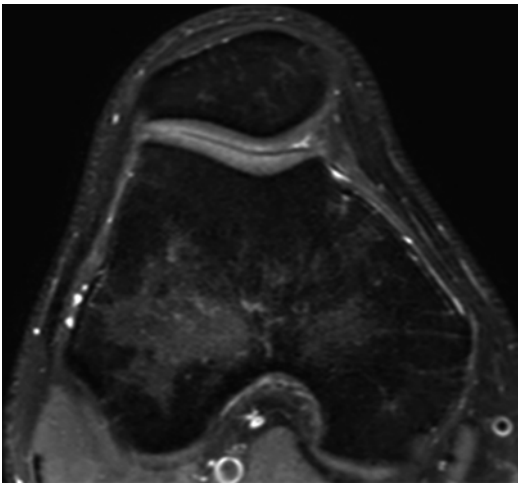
Reliability of MR imaging analysis in trochlear dysplasia. Flat subchondral bone is homogeneously covered by articular cartilage
